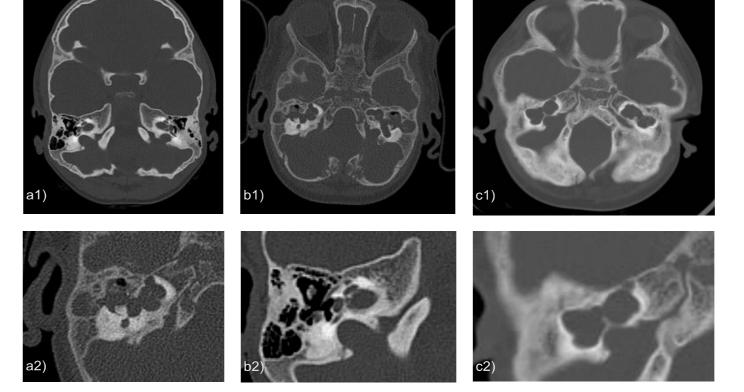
CT-scans inner ear
